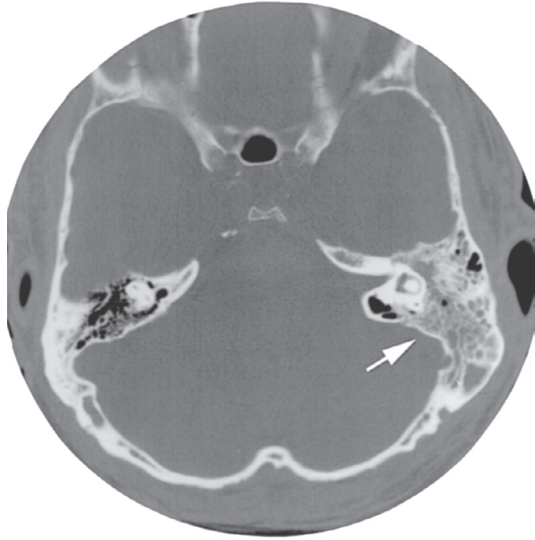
CT scan of mastoiditis. (From McWhorter AJ, Limb CJ, Niparko JK: Otolgic and skull base emergencies. In Eisele DW, McQuone SJ, editors: Emergencies of the head and neck, St. Louis, 2000, Mosby, p 384.)
